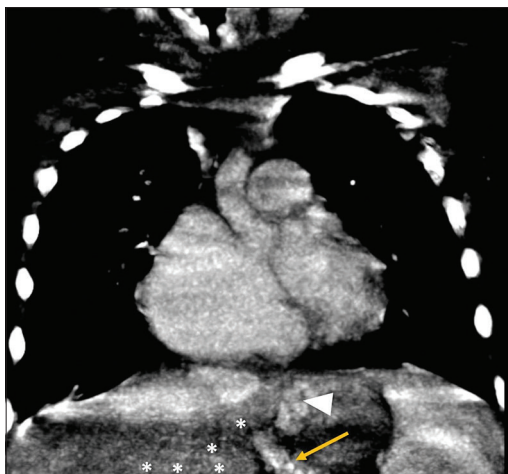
Contrast enhanced computed tomography showing ill-defined portal vein (*) with peri-esophageal collaterals (arrow)
